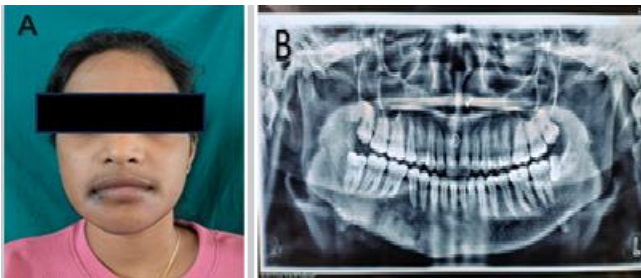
Post- operative (A) Clinical picture, (B) Orthopantomogram of the patient
